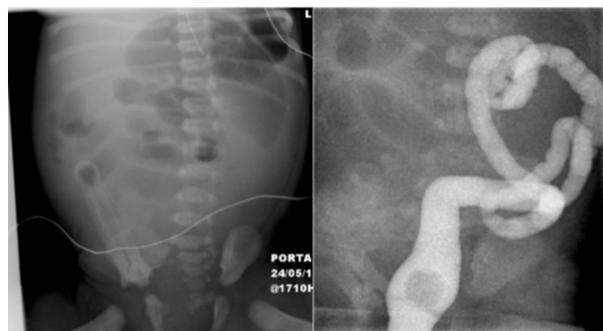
Plain abdominal radiograph and contrast enema of Case 2 adjacent proximal bowel loops did appear dilated (Fig 2B).
